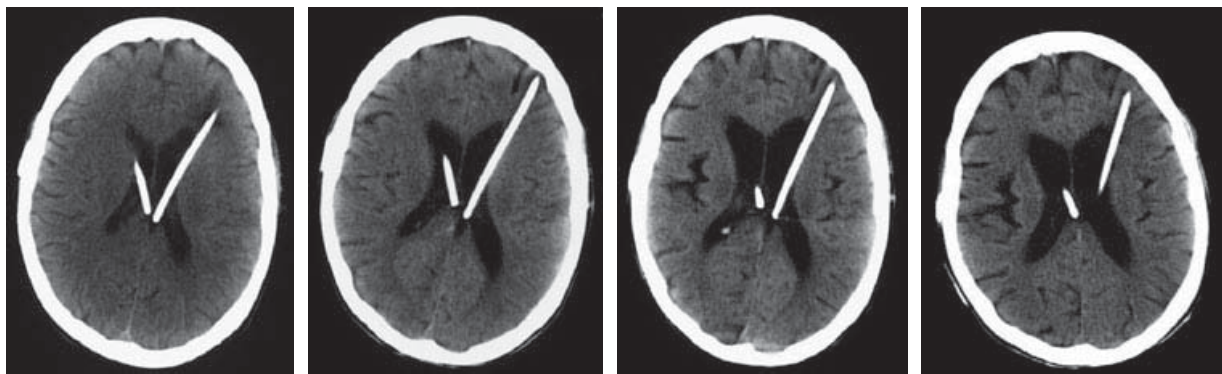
Sequential follow-up CT scans over 3 months in patient with variant CJD (patient 2) receiving continuous intraventricular infusions of pentosan polysulphate.
